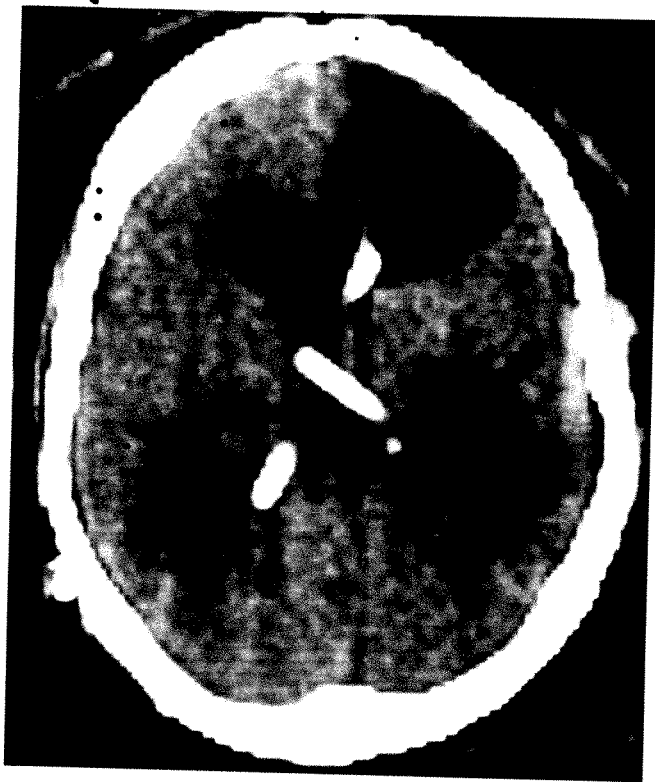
Ventriculitis Chronic ventriculitis in 17-year-old male with long history of CNS infections which began with right frontal monilia abscess and meningitis secondary to depressed fracture. Hydrocephalus followed initial infection and was treated with shunts; repeated *Monilia* infections necessitated many shunt revisions. CT shows hydrocephalus and multiple ventricular shunts. Focal dilatation of right frontal horn consistent with porencephaly at site of previous abscess. Marked irregularity of ventricular margins in atria and occipital horns reflects subependymal gliosis characteristic of chronic granulomatous or fungal infection. Right temporal lobectomy performed subsequent to CT scan because of seizures. Subependymal gliosis with adjacent old microabscess found.
